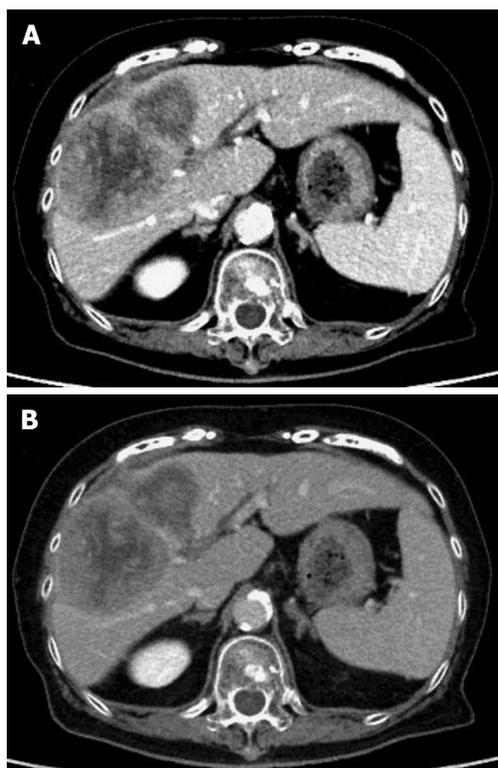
Contrast enhanced computed tomography scan showed a tumor located in the right anterior compartment of the liver with extrahepatic hematoma. The tumors were hyperattenuating relative to the noncancerous liver parenchyma on arterial-phase (A) and hypo- or isoattenuating on delayed phase (B).
